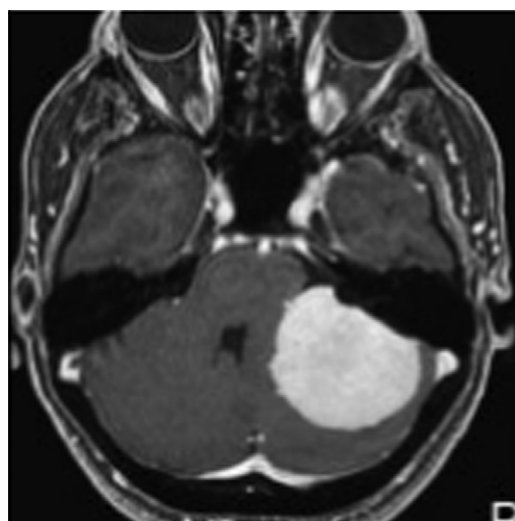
MRI of the brain, T1-weighted axial image with Gadolinium enhancement showing left cerebellopontine angle meningioma.
